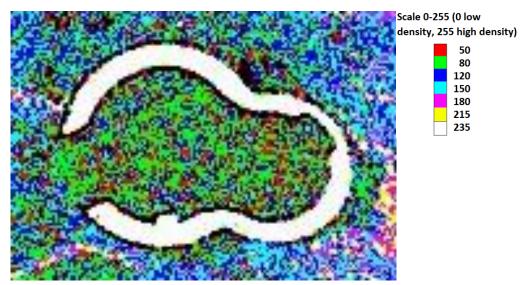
Shows a CT image of the tibial cone in the axial plane, with the application of a LUT via ImageJ having been applied to in order to determine the possibility of in-growth. Red shows low density, and white shows high density.
